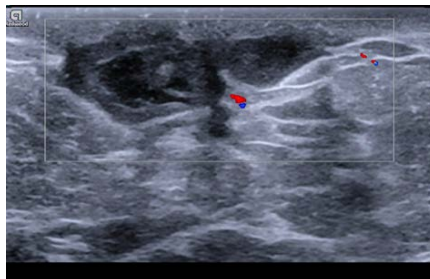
Targeted ultrasound with doppler flow of the left subareolar area showed a complex fluid collection measuring $0.9 \times 3.5 \times 0.9$ cm, suggestive of an abscess.
